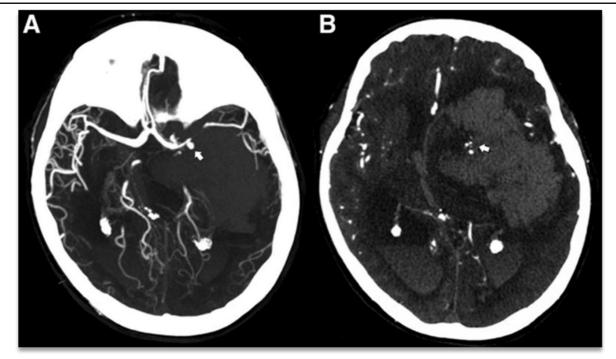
1 Shows hyperdense spot sign within and periphery of hematoma during contrast CT- Angiogram study which is discontinuous from the vasculature.
